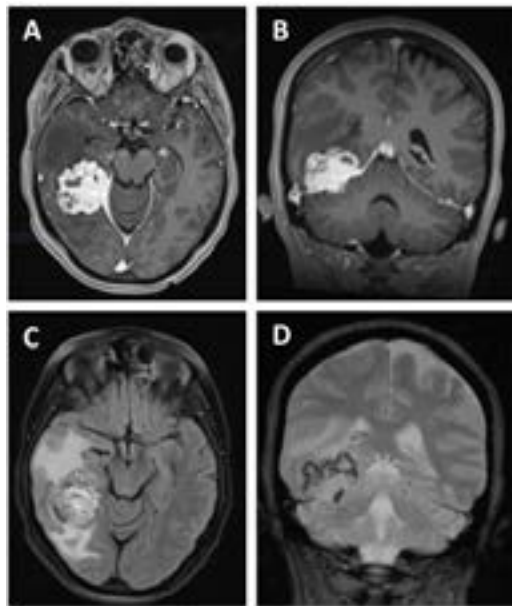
pre-operative MRI images showing an enhancing ventricular lesion with a wide choral base and dorsal tail sign: (A,B) T1 with gadolinium contrast; (C) T2 FLAIR; and (D) T2 gradient echo.
